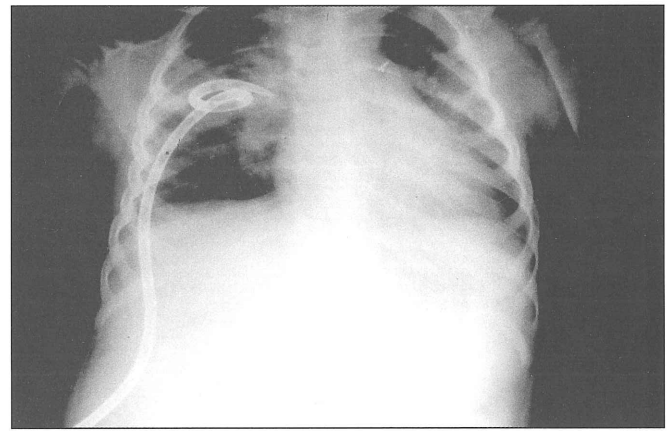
Plain chest radiograph after treatment shows prominent decrease of the abscess cavity size. The drainage catheter in the cavity is seen as well.
